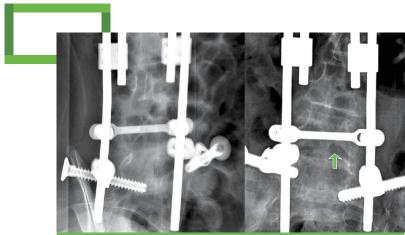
Pre-lumbar puncture X-rays
